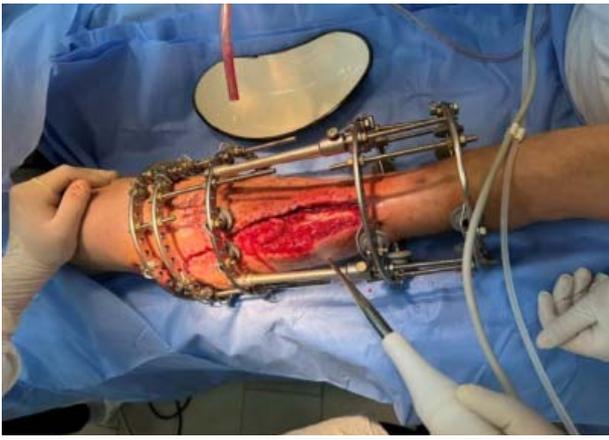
Performing ultrasonic cavitation in a patient with CCTMI of the right tibia
